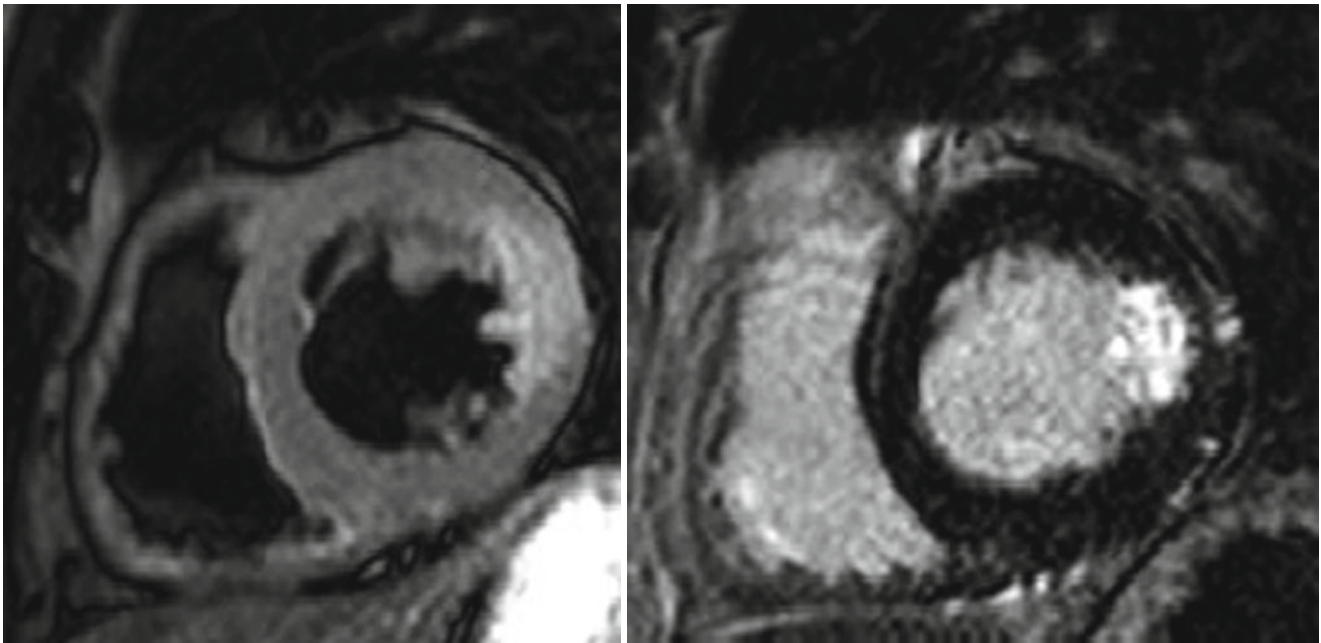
The discrepancy between T2WI and LGE image. T2-weighted image shows transmurular edema extending toward all lateral walls. Note the absence of LGE involved by edema representing reversibly damaged myocardium
